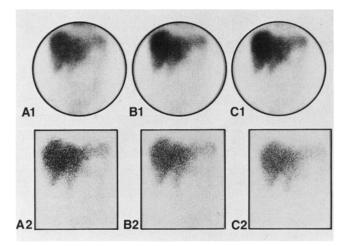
Normal pancreatic scans: scintigrams (A1, B1, C1) demonstrate normal study at 10, 20, and 30 min respectively. Comparative tomograms (A2, B2, C2) are displayed at tomoplane 4, 5, 6 respectively.
